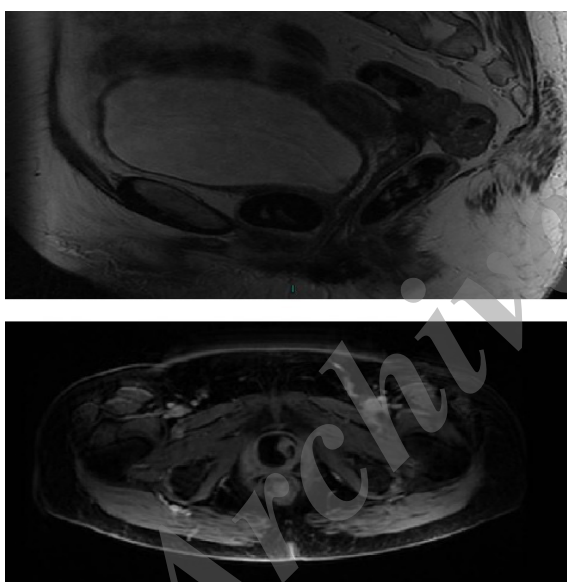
Magnetic resonance imaging (MRI) demonstrating a suspicious area around the urethra.
